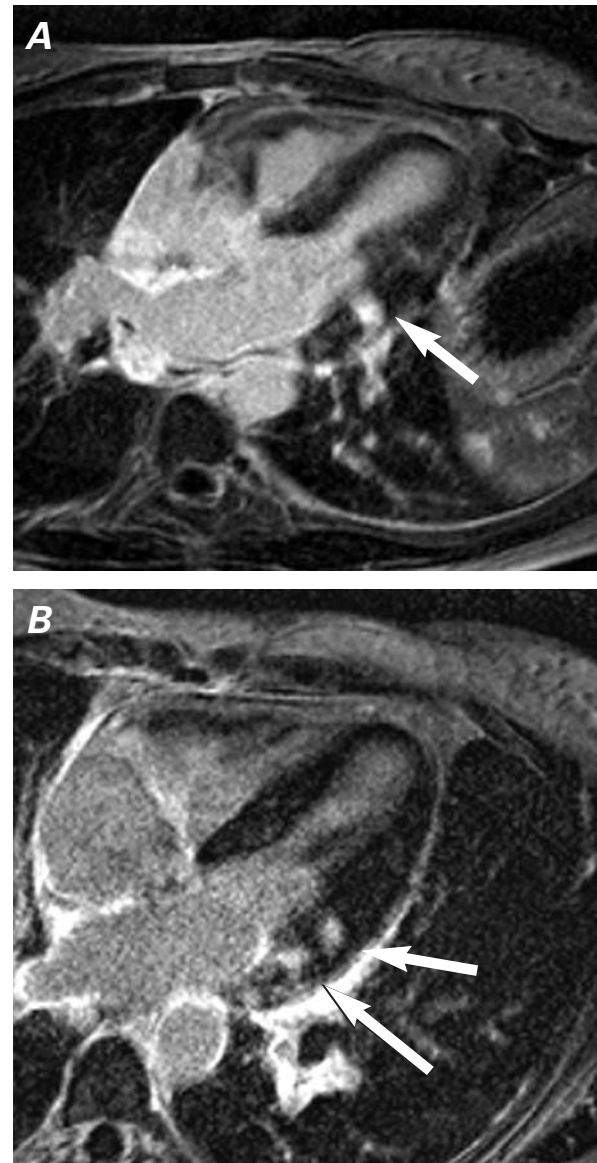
DE-MRI images of the left ventricular outflow tract (A) and the 4-chamber projections (B) show patchy infiltration of the left ventricular lateral wall (arrows).
